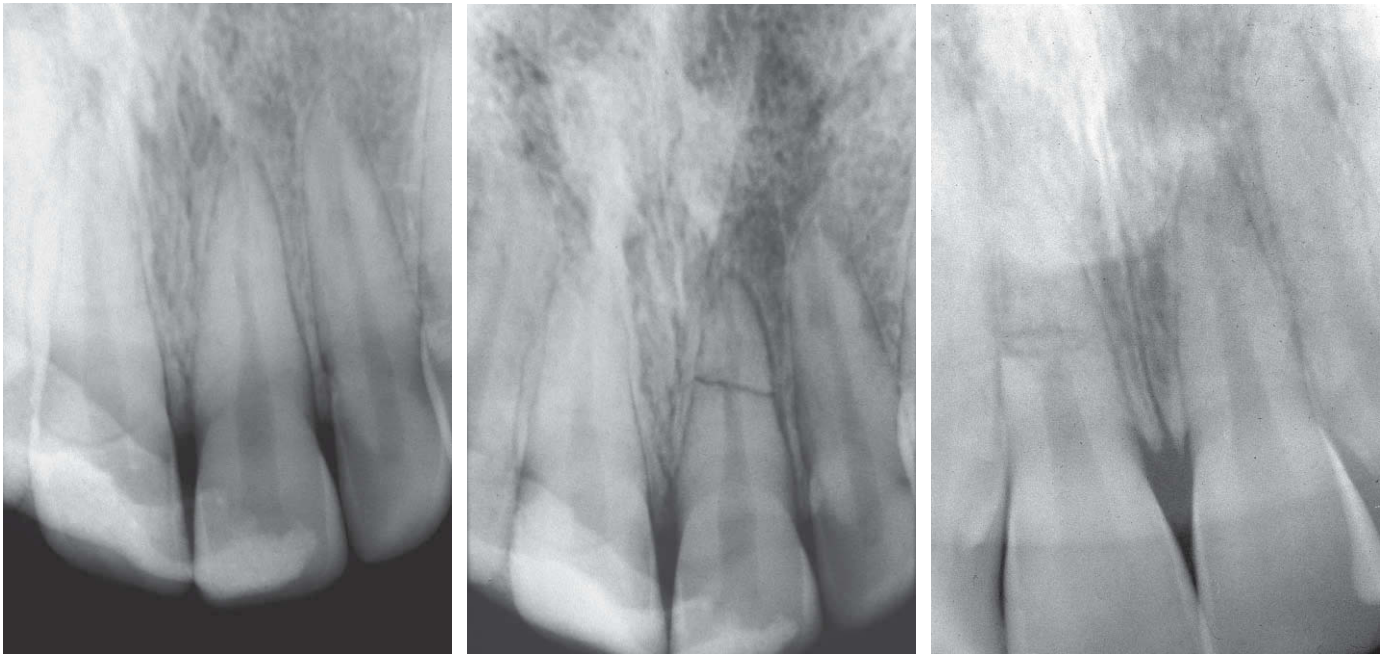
A-C, Over time, a fracture in the coronal third of the root may begin to communicate to the sulcus subsequent to periodontal disease. The radiographs depict the bone loss over a period of 3 years. D and E, Subsequent to the gingival communication, bone loss rapidly ensued, with the result being a severely compromised root. Extraction was ultimately recommended.
